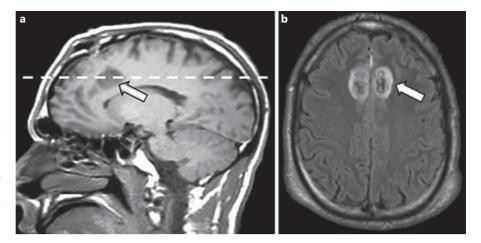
Representative postoperative MRI images following bilateral anterior cingulotomy. A T1-weighted sagittal image (a) and T2-weighted axial image (b) are shown, with white arrows indicating the lesion position. Reprinted from Shields et al. [30], copyright 2008, with permission from Elsevier.
